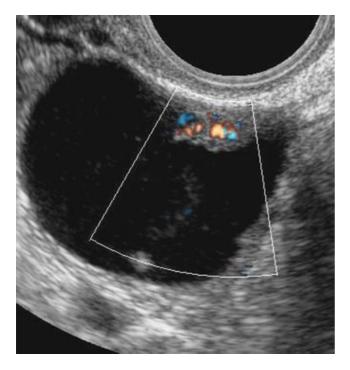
Power Doppler ultrasound image showing cyst with vascularized papilla: serous borderline ovarian tumor.
